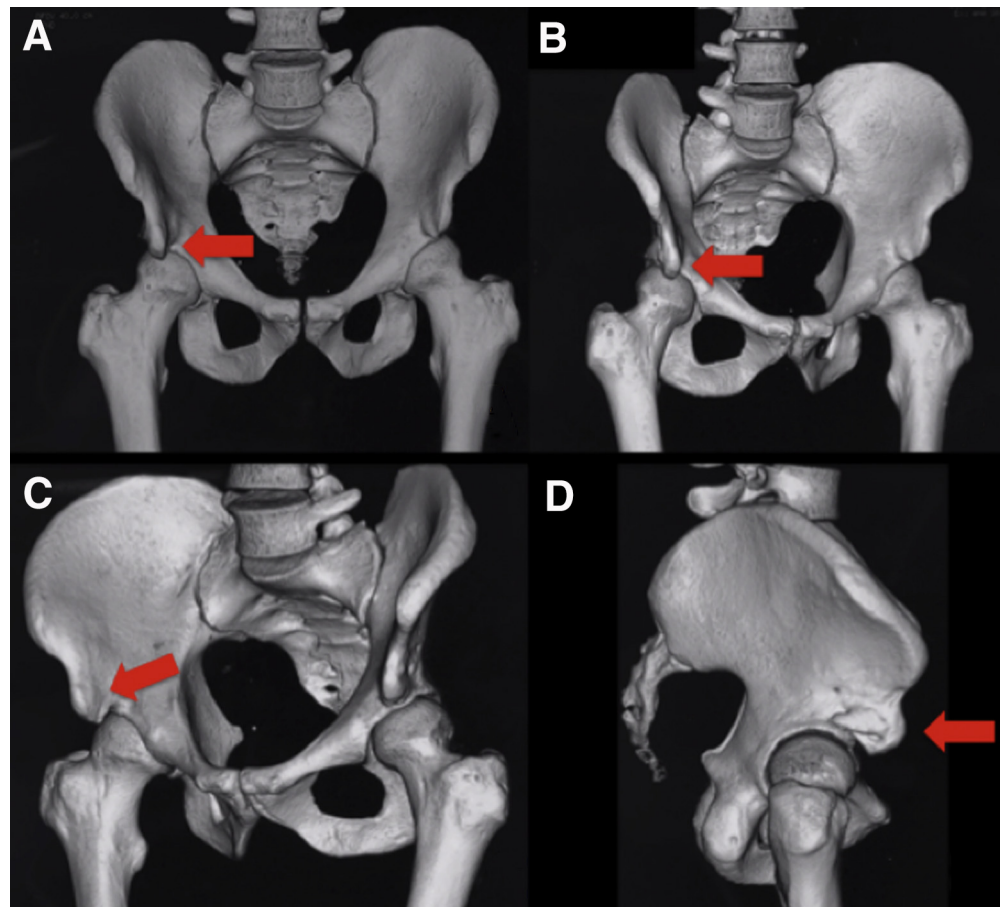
(A-D) Series of preoperative 3-dimensional computed tomographic scans revealing a grade III subspine impingement (red arrow).
